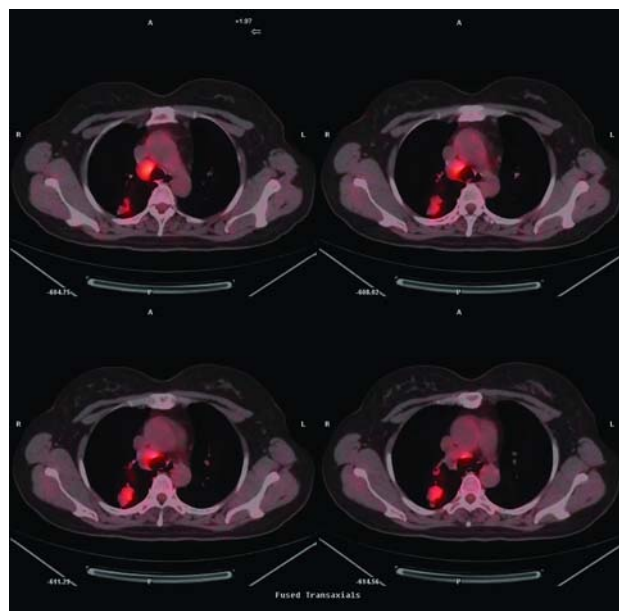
^{18}F -FDG PET/CT images of case five patient (transaxial images). The four continuous layers of the PET/CT fused images of the patient. The two elevated-FDG uptake lesions, 2.6 cm and 1.6 cm in diameters, were detected in the upper lobe of the right lung. The SUV_{max} was 5.6 and 2.9, respectively. Another lesion was detected in the upper mediastinum, 2.3 cm in diameter, SUV_{max} was 6
